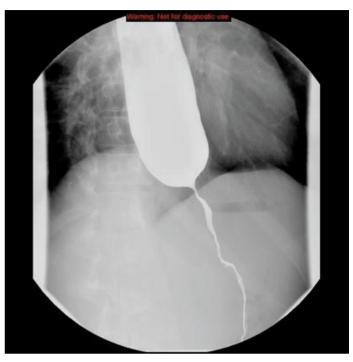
X-ray of a patient with achalasia during a barium swallow test. A wide, atone oesophagus and a thin gastro-oesophageal junction (Bird's beak) is seen. Image from https://pediatricimaging.wikispaces.com/Achalasia, reuse under CC BY-NC-ND 3.0.
